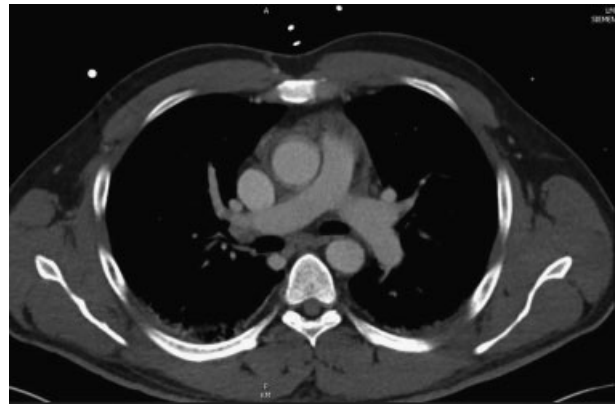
Coronal angio computed tomography of the chest showing pericardial effusion.
